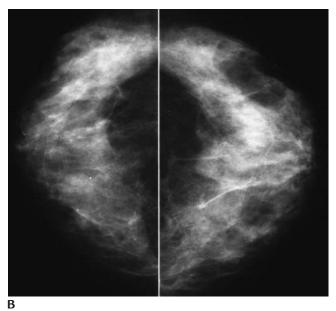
Cysts. (A) Craniocaudal views demonstrating multiple masses of varying sizes and densities bilaterally. Multiple cysts are imaged on ultrasound (not shown). (B) Subsequent mammogram demonstrates decrease in size or resolution of the cysts. Cysts often develop as a preamble to menopause and usually resolve after menopause unless the patient is placed on hormone replacement therapy. They are hormonally responsive such that they are characterized by fluctuations in size and associated tenderness.
